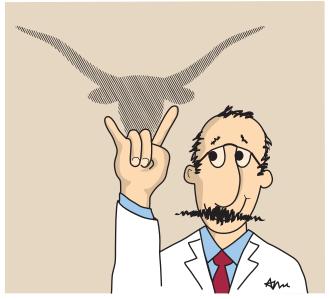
A shadowgraph is analogous to a radiograph. (Dedicated to Xie Nan Zhu, Guangzhou, People's Republic of China.)
